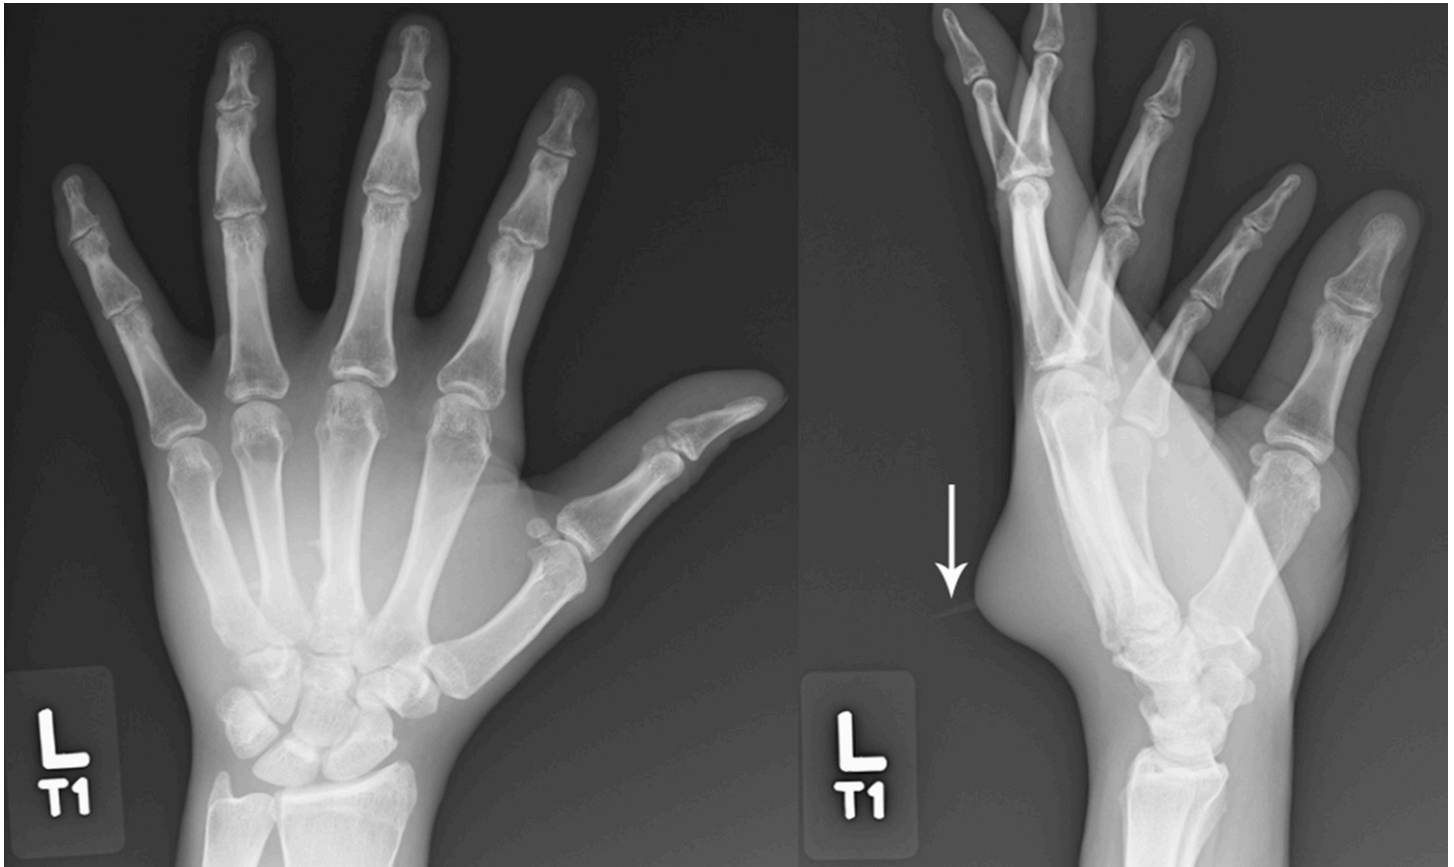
Anteroposterior and lateral radiographs of the patient's left hand with the foreign object visible outside the hand (arrow).
